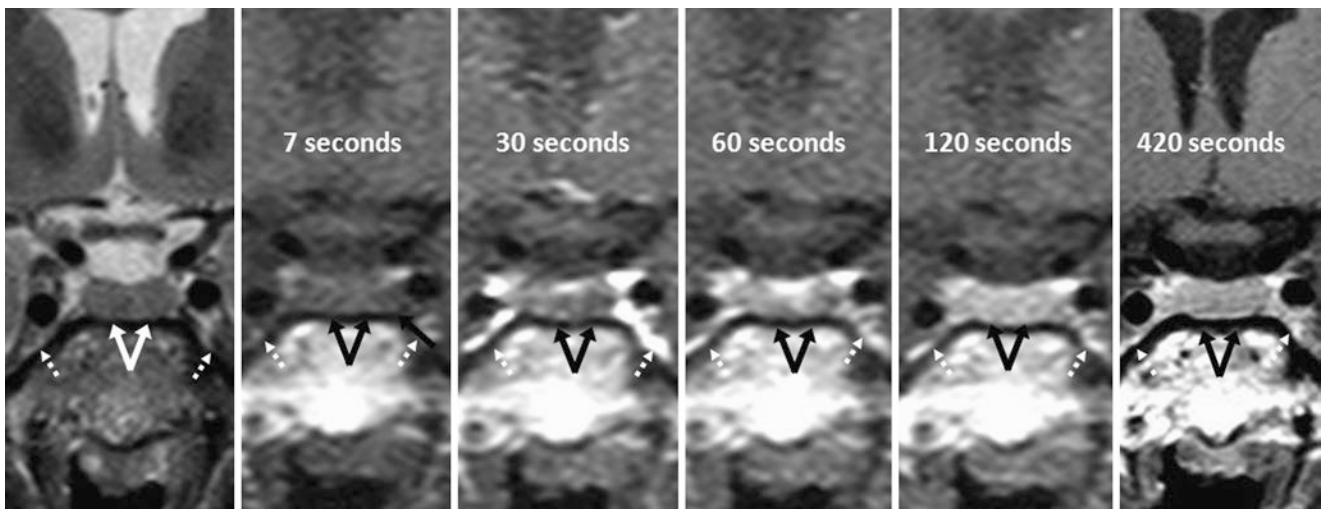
Normal delayed enhancement peripherally. In a 35-year-old female with vision loss, 3 T MRI (interpreted as normal) coronal T2WI (*left*), and serial dynamic enhanced T1WIs from time 7–420 s post-contrast depict the lateral areas (*arrows*) filling with contrast, although
